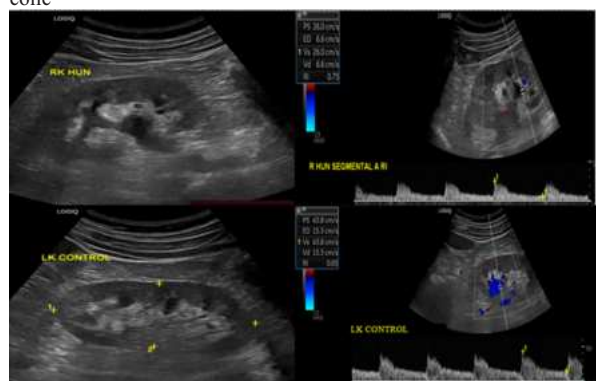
Grey scale USG & BDoppler US demonstrating an RI value of 0.75 in the lower pole of right kidney (obstructed kidney) and RI value of 0.65 in the lower pole of left kidney (unobstructed kidney)
